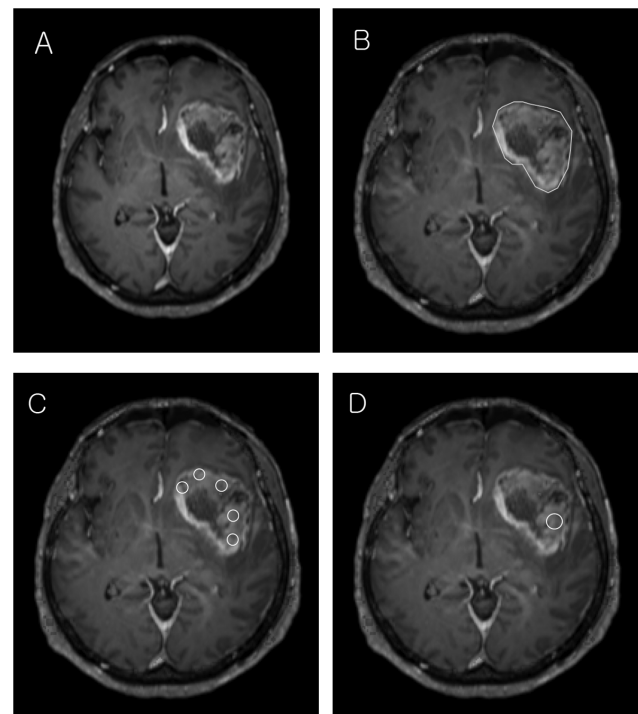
Representative case. A 43-year-old female with biopsy proven GBM. On Gd enhanced T1-weighted image (A), GBM shows heterogeneous enhancement in the left basal ganglia. ADC maps were coregistered to Gd enhanced T1-weighted image. Whole tumor volume ROI (ROI₁) was drawn along the tumor border for each consecutive slice of the coregistered image (B). Multiple circular ROIs (ROI₂) were drawn on coregistered image (area = 10 mm²) (C). A single circular ROI (ROI₃) was drawn on any solid area, avoiding necrosis (area = 20 mm²) in coregistered image (D).
